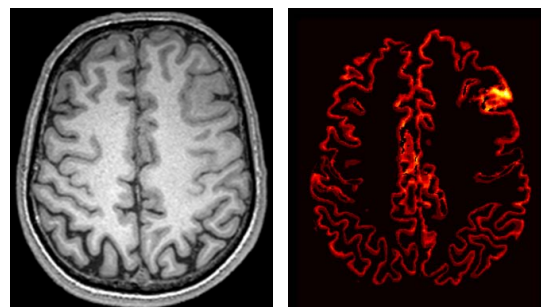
Example MRI data: (a) original T1-w slice, (b) cortical thickness map.
